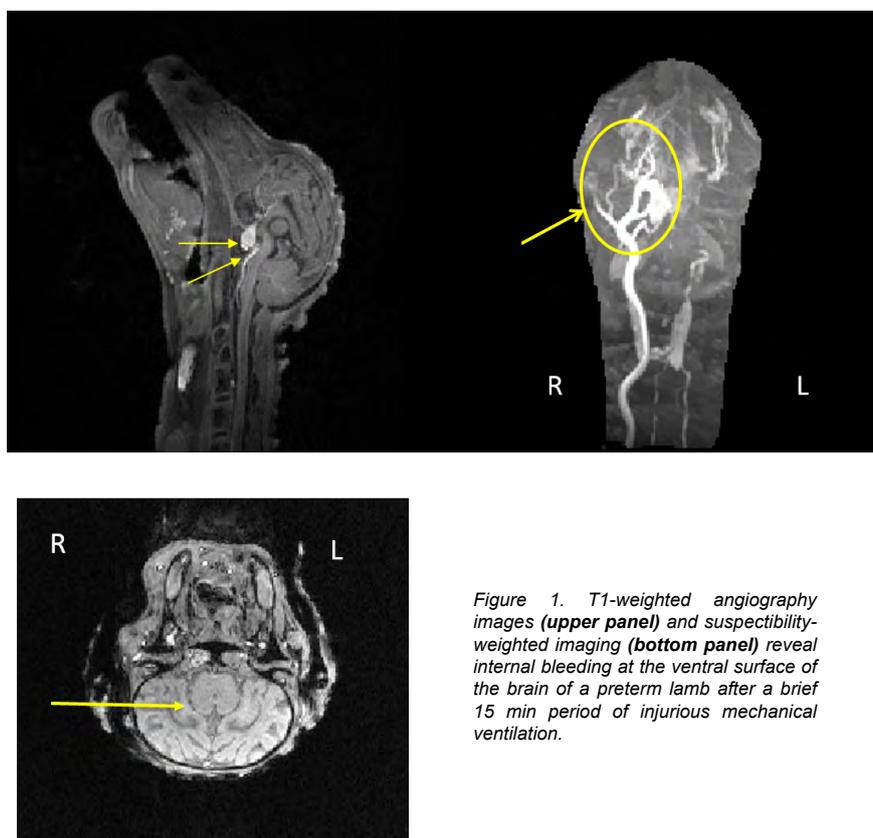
T1-weighted angiography images (upper panel) and susceptibility-weighted imaging (bottom panel) reveal internal bleeding at the ventral surface of the brain of a preterm lamb after a brief 15 min period of injurious mechanical ventilation.
